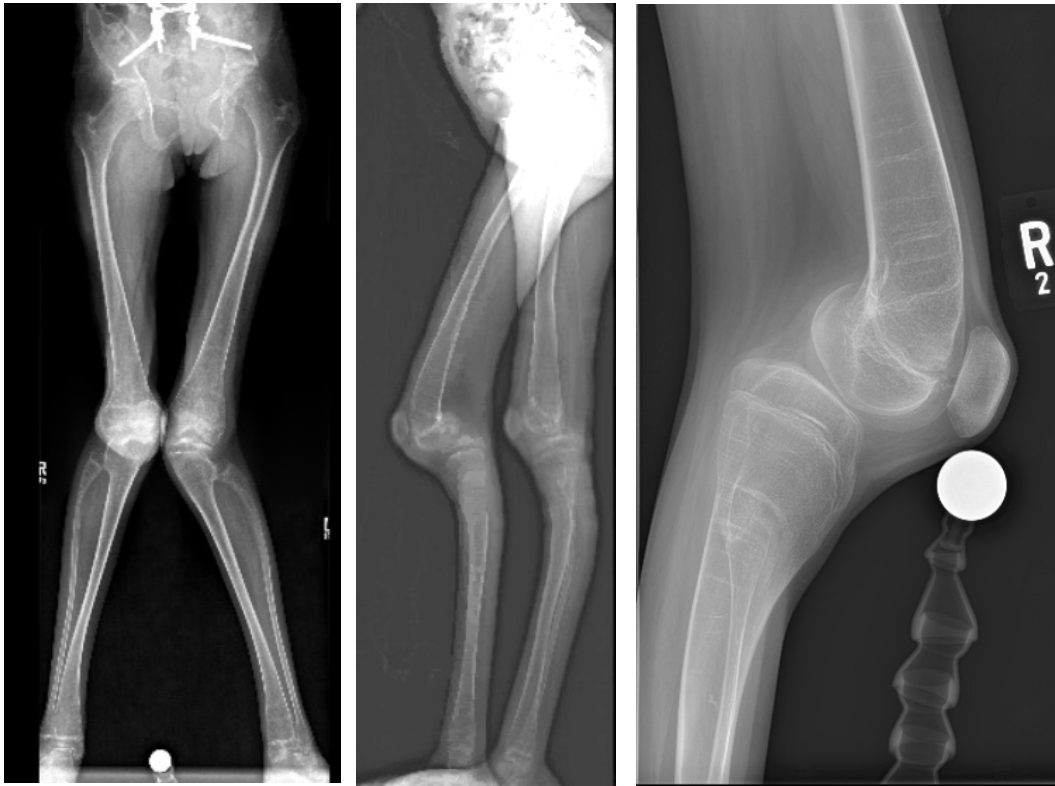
Standing AP (a) and lateral (b) preoperative radiographs of a 12-year-old girl with Marfan syndrome characterized by severe lower extremity rotational and angular deformity with knee subluxation as seen in coned lateral right knee radiograph (c).
